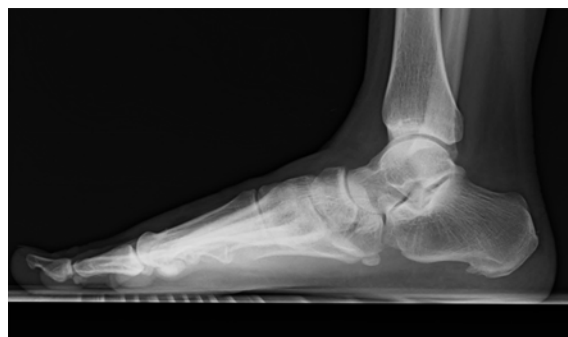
A weight-bearing lateral radiograph showing the projection of the inferior heel spur: 5 mm (in-length) with calcaneal pitch angle 10° on right foot
